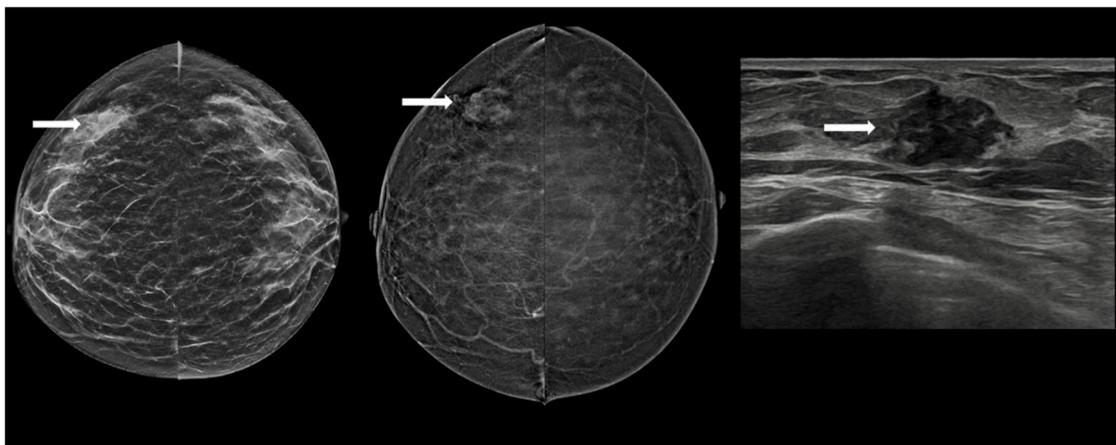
False positive interpretation; contrast enhanced mammography images of a 46-year-old woman. Craniocaudal view, low energy image (left) of the right breast shows a subtle asymmetry (white arrow) in the outer right breast; recombined image (middle) shows heterogeneous enhancement within the mass (white arrow) and the correlative ultrasound image (right) shows an irregular hypoechoic mass whose margins are not circumscribed. Ultrasound guided vacuum assisted biopsy using 9-gauge needle revealed sclerosing adenosis with no in-situ component or invasive malignancy.
